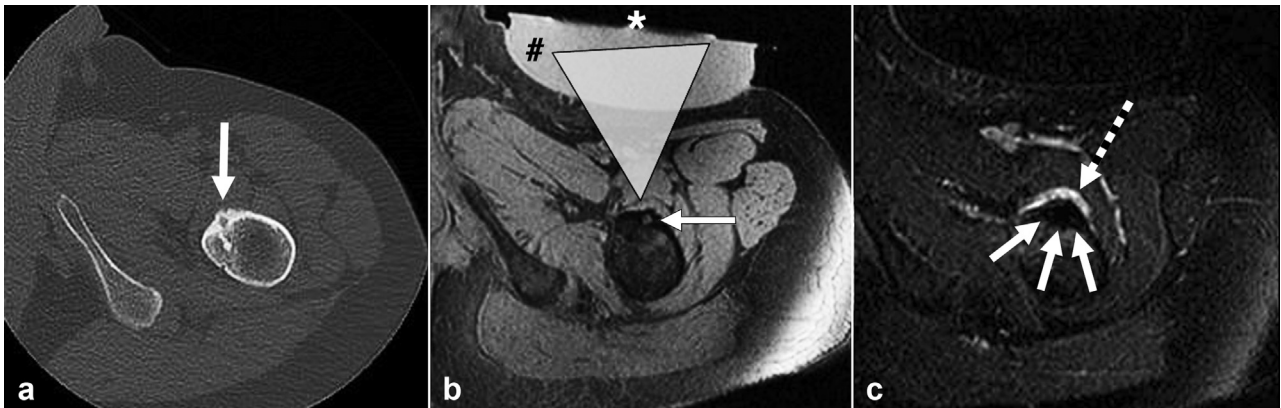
Cortical osteoid osteoma of the femur. (a) Axial CT image of the lesion (arrow). Note the thin layer of bone bordering the lesion. (b) Intraprocedural image during MRgFUS treatment: * marks the therapeutic US transducer, # marks the water bag that creates space between the transducer and the lesion to transmit and focus the US beam, the gray triangle represents the US beam, and the white arrow indicates the nidus. (c) Axial MR imaging after treatment (contrast enhanced T1-weighted image with fat suppression) showed the absence of contrast enhancement in and around the nidus (solid arrows), confirming successful ablation. Dashed arrow indicates the reactive phenomenon on the bone surface.
